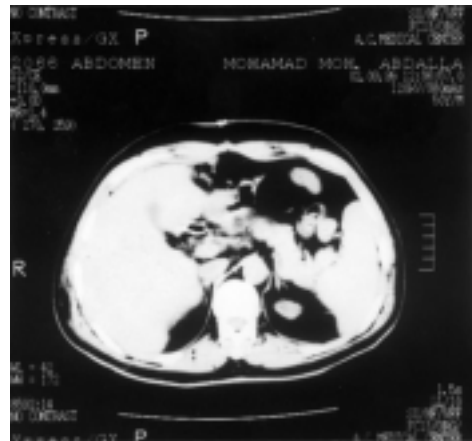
Postoperative CT after segmentectomy (II,III) (PHRR= 14.2%).
